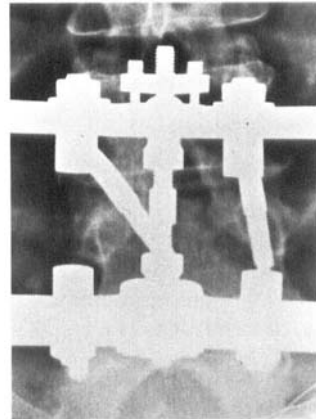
In the AP radiograph, the left L4 Schanz screw lies medially to the pedicle. This patient had a transient L5 root lesion.
